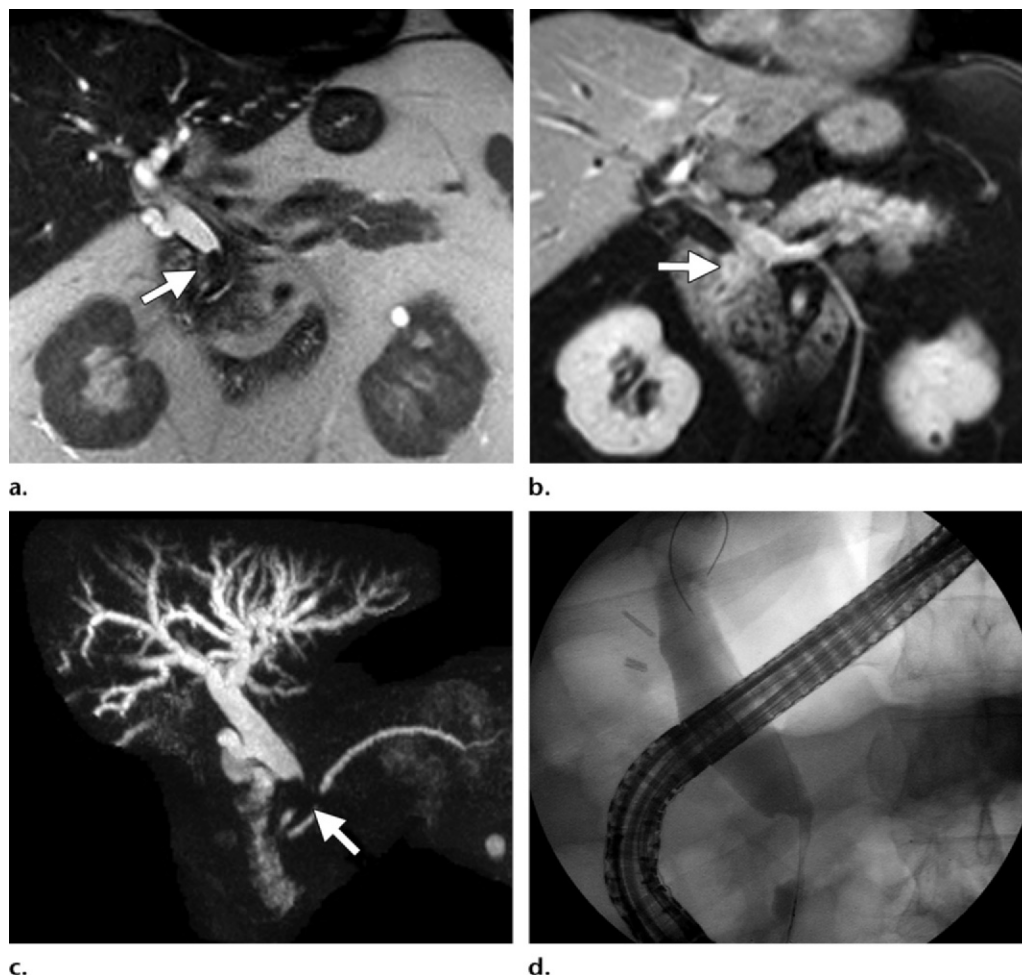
Ampullary adenoma in a 65-year-old man. (a) Coronal T2-weighted HASTE MR image shows a lobulated mass in the region of the ampulla (arrow), with mild dilatation of the CBD and pancreatic duct. (b) Image from endoscopic US shows a filling defect (arrow) caused by the echogenic lobulated mass, which arises from the region of the ampulla and fills the distal CBD.
